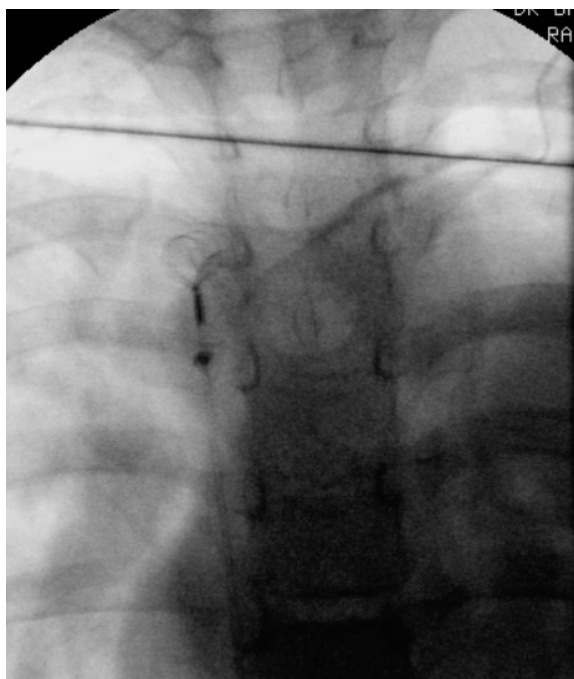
A chest radiograph showing the migrated segment of the catheter
